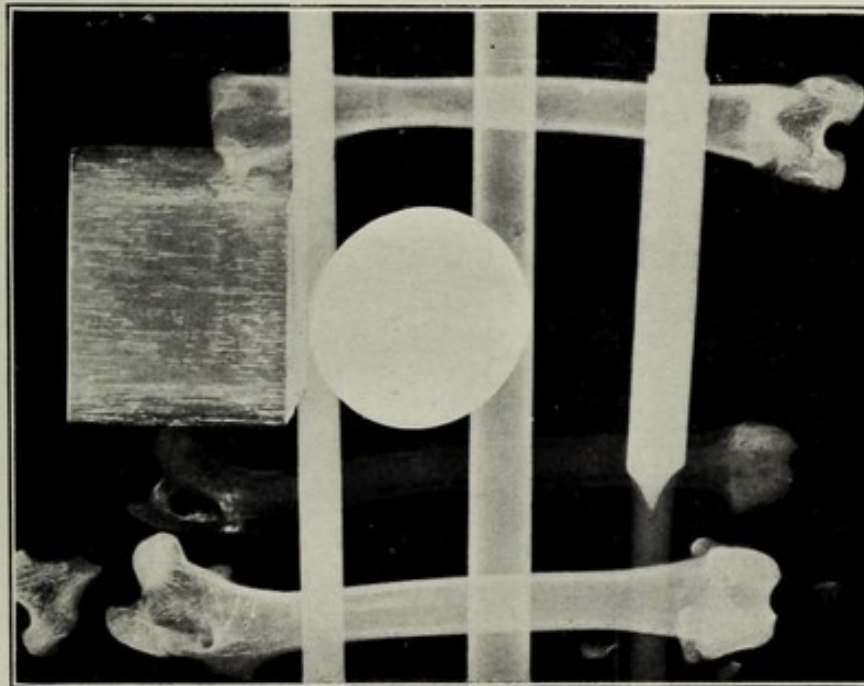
Radiographic ambiguity.*
